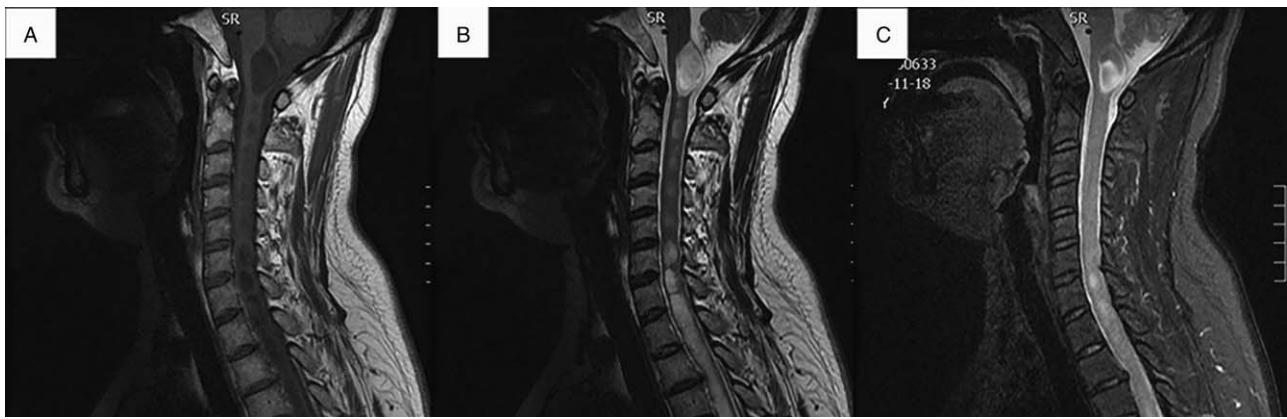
Preoperative magnetic resonance imaging (MRI). (A) Sagittal magnetic resonance T1-weighted imaging showed a cystic lesion with hypointensity in the foramen magnum region. (B) Sagittal T2-weighted imaging showed the lesion was heterogeneously hyperintense. (C) Sagittal contrasted T1-weighted imaging demonstrated heterogeneous enhancement in the cystic wall.
